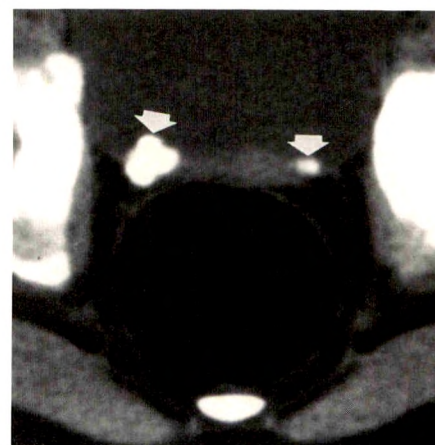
Nonenhanced axial CT scan of bladder shows portion of each subureteric Teflon injection (arrows). At this level Teflon appears to be in bladder wall, in contrast to sonogram, where it projected into bladder lumen.
